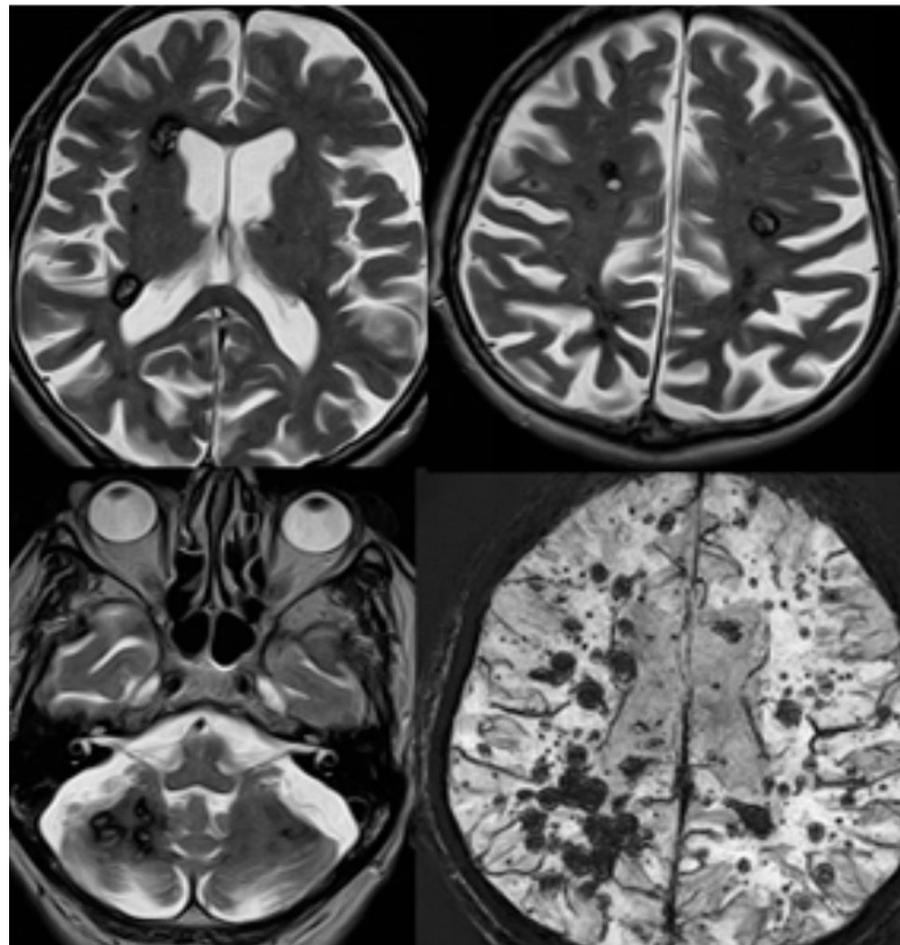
Cerebral MRI showed unenhanced, well defined, multiple lesions between 3-17 mm, with iso-hyperintensity T1, T2, and FLAIR, spread out periventricularly, subcortically, in frontal, temporal, parietal lobes and subtentorially, right and left cerebellum
